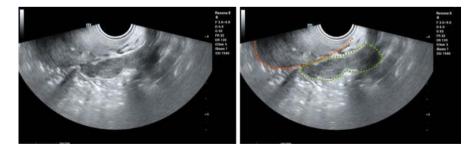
B-mode ultrasound shows a solid hypoechoic mass in the adnexal area with a sausage-like shape and irregular contours. The uterus is outlined in orange; the solid hypoechoic tumor circled in green
